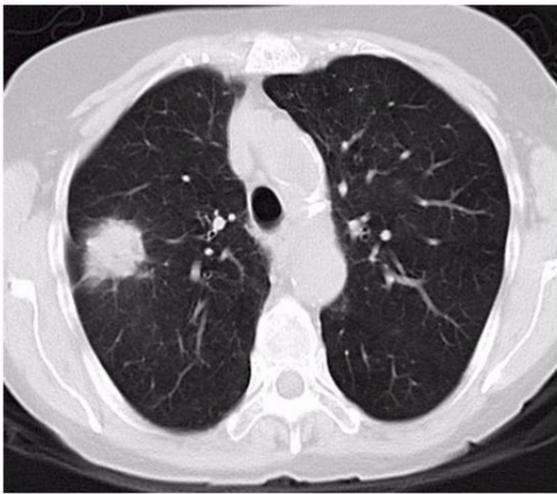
The lung cancer on CT thorax
